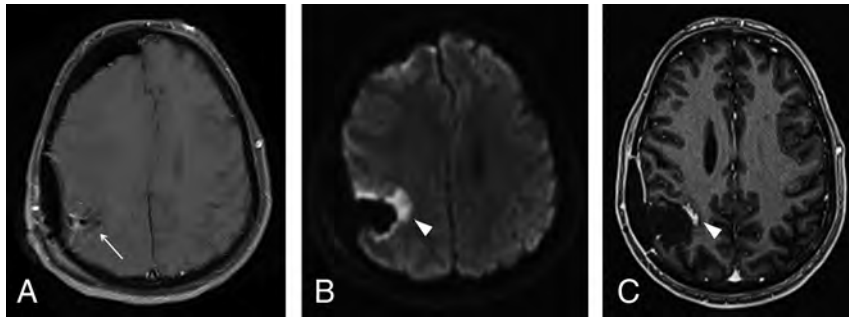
Postoperative findings after GBM resection in the right parietal lobe (not shown) in a 55-year-old man. *A*, Axial contrast-enhanced T1-weighted image in the immediate postoperative period demonstrates a fluid-filled surgical cavity (*arrow*) without any enhancing lesions, which is defined as gross total resection. *B*, An axial diffusion-weighted image shows marked restricted diffusion in the margins of the cavity (*arrowhead*), representing cytotoxic edema related to surgical manipulation. *C*, Axial contrast-enhanced T1-weighted image obtained 3 months after an operation shows the development of an enhancing focus in the surgical bed (*arrowhead*), corresponding to development of granulation tissue in the area of previously restricted diffusion, also a typical and predictable postoperative feature, which should not be misdiagnosed as recurrent or residual tumor.
